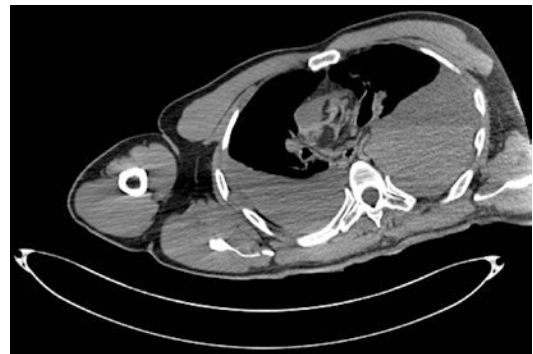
Axial noncontrast computed tomography (CT) scan showing collapse of vascular structures (the heart and vessels) with pleural hyperdense effusion due to aortic rupture
